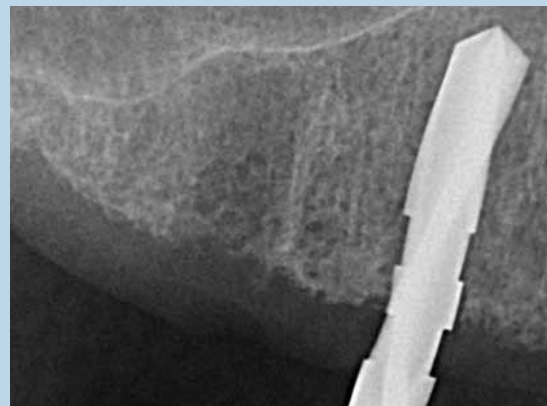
Periapical radiograph of 3.3 mm Twist drill in position
